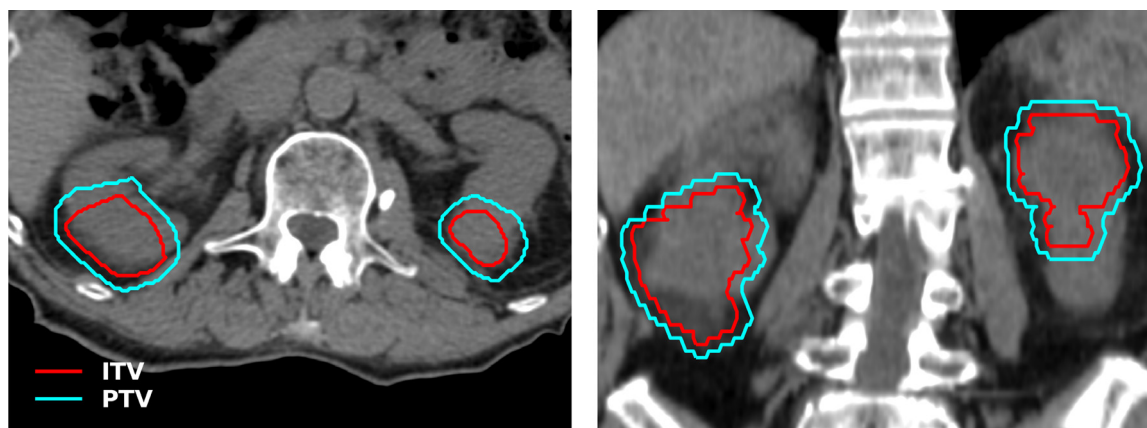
Representative axial (left) and coronal (right) sections of planning computed tomography showing internal target volumes (ITVs) (red) and planning target volumes (PTVs) (cyan).
